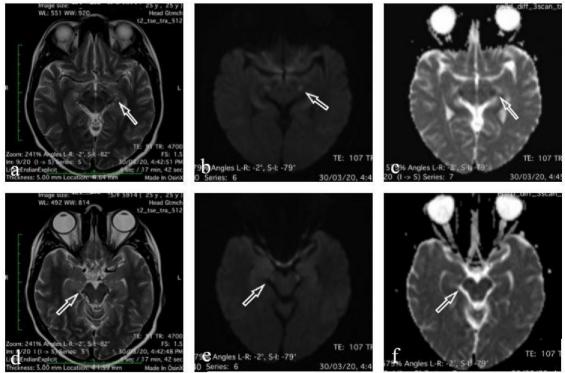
MRI axial sections of the same patient showing T2W image (a,d), DWI (b, e) and corresponding ADC mapping (c,f) reveals T2 hyperintensity with diffusion restriction (arrows) in bilateral cerebral peduncle of midbrain.
